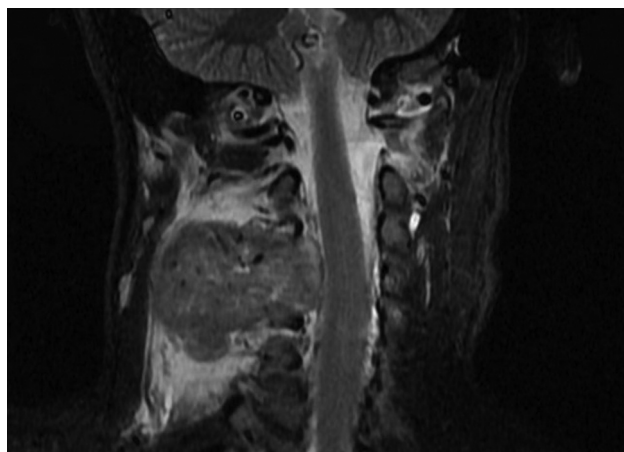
Magnetic resonance imaging with C3 involvement without spinal compromise.
